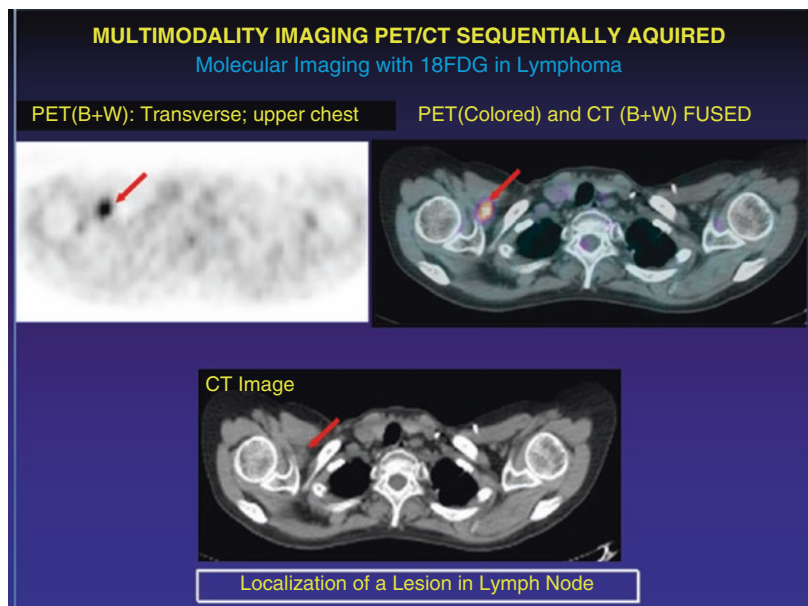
PET/CT studies, multimodality imaging, of malignant tumor (lymphoma). This study enabled the characterization of activity (right axilla) as due to an abnormal, enlarged (lymphomatous) lymph node
